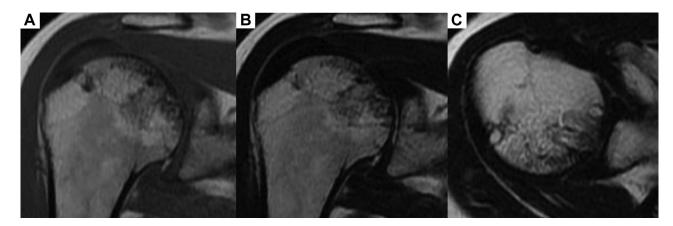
Magnetic resonance imaging 2 years after surgery. Complete graft integration and no recurrence of osteonecrosis were noted. (A) Oblique coronal T1-weighted image of the right shoulder. (B) Oblique coronal T2-weighted image of the right shoulder. (C) Axial T2-weighted image of the right shoulder.
